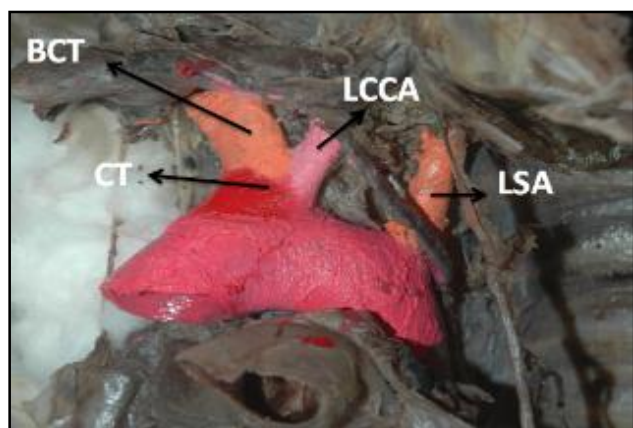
Shows Common Trunk (CT) for Left Common Carotid and Brachiocephalic Trunk
